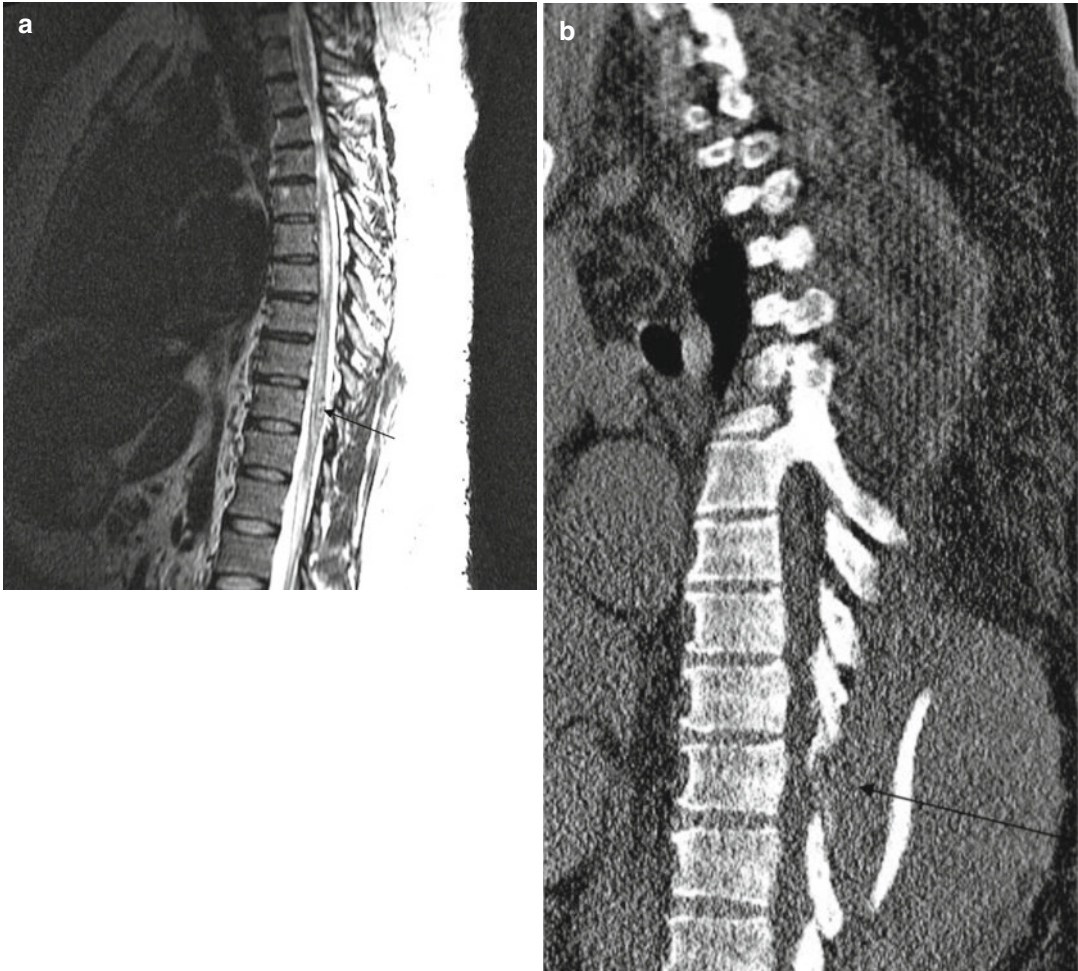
(a) Sagittal MRI of T-spine demonstrating hemorrhaged cavernoma at T7 level (*arrow*). (b) Sagittal CT of T-spine demonstrating hematoma at post-laminectomy site compressing spinal cord (*arrow*)
